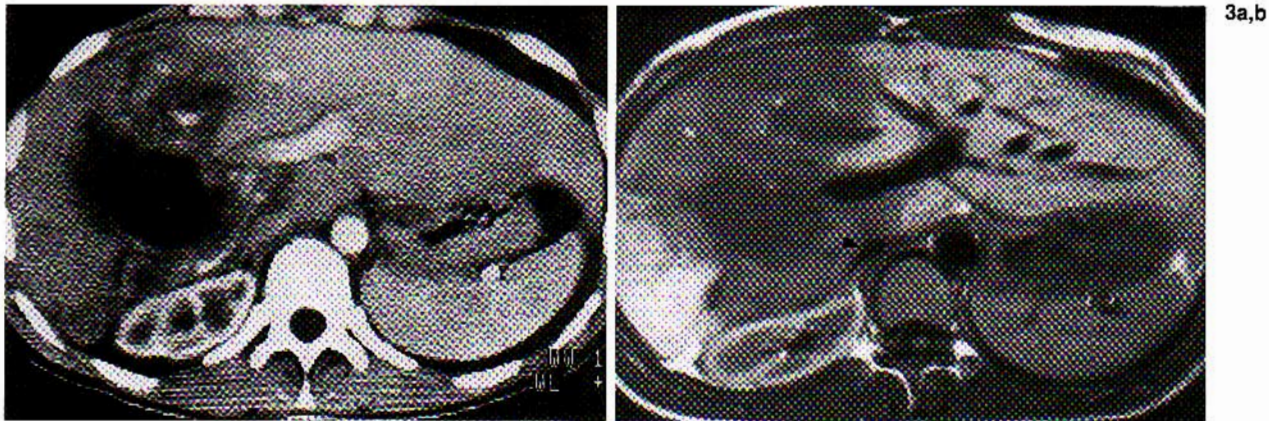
a: Postiodine CT scan shows large calcified and necrotic mass in the right and medial segment of left lobes with obstruction of the right portal vein. b: T1-weighted MR image (TR 600 ms) shows the lesion edges as well as the extension to the portal vessels. The blood flow in the vena cava is unobstructed (arrowhead).
